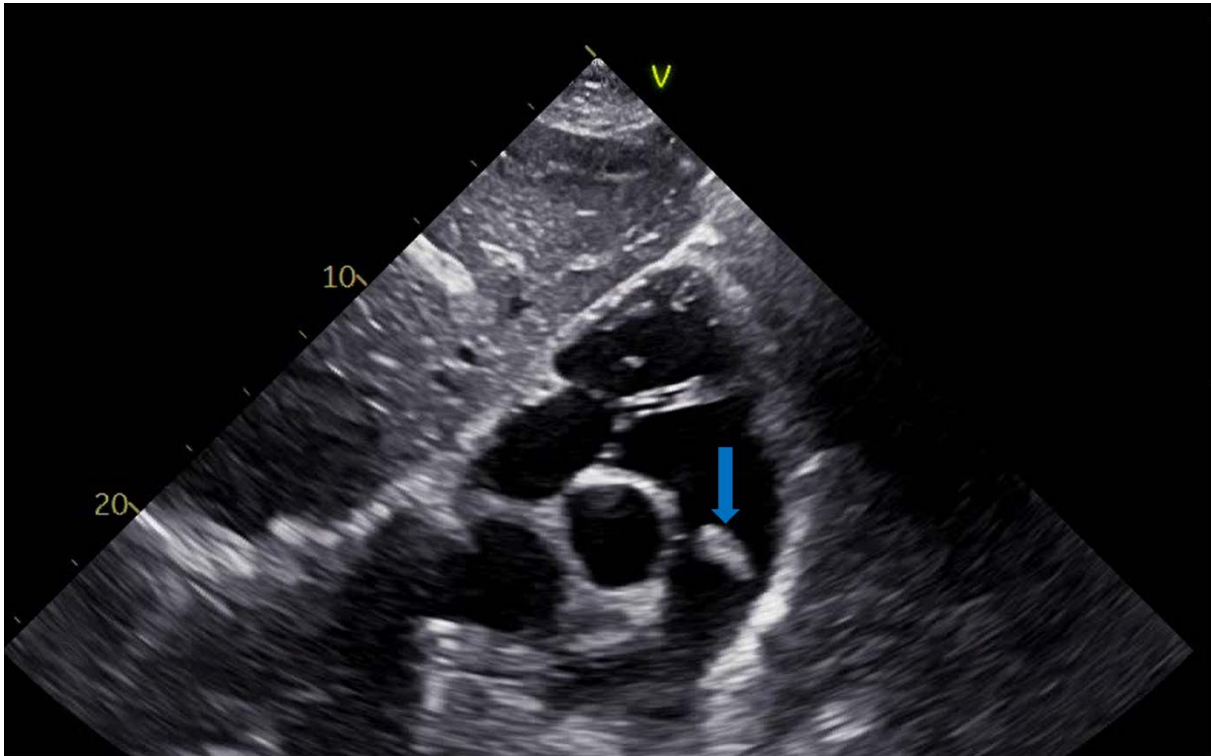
C. Echocardiographic examination — image of vegetation on the pulmonary valve (blue arrow)
